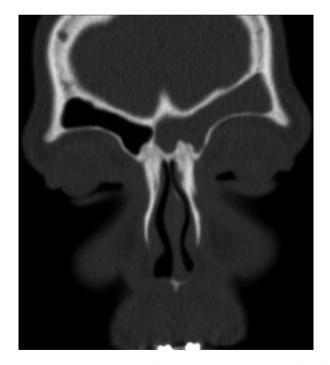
Typical non-contrast coronal sinus CT scan of an adolescent male with unilateral frontal headache demonstrating isolated frontal sinusitis
